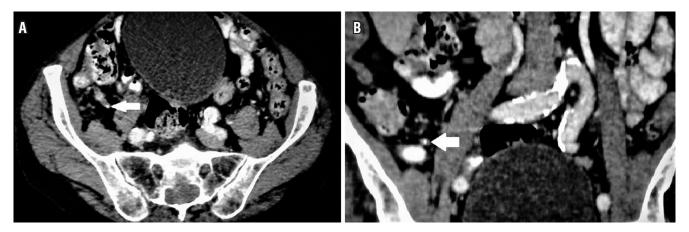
Computed tomography showing hardened feces in the opening of the appendix (white arrow). A. Cross section. B. Crown section.
